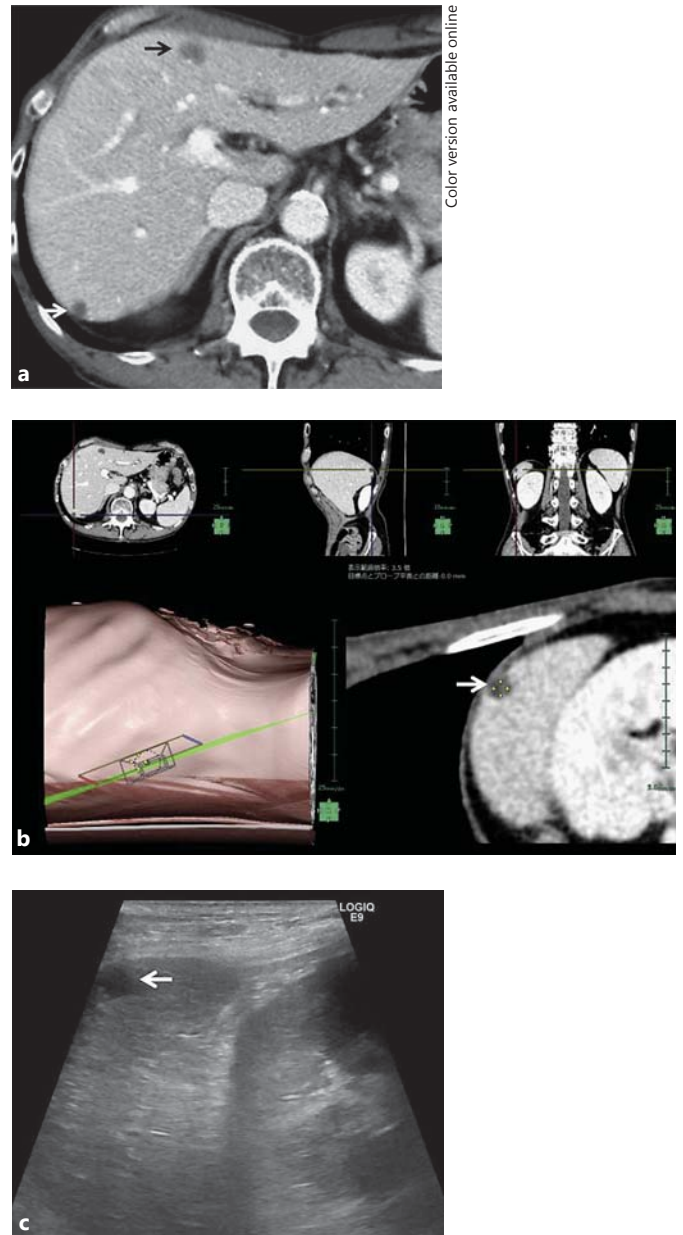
Imaging of a 66-year-old man with liver cysts. a Transverse portal phase CT shows two cysts (arrows) in segment III and VI of the liver. b Screen shot shows setting windows for VINCENT. Upper images show the transverse, sagittal, and coronal views for the cyst in segment VI. The lower left image shows that the transducer angle in the plane of the body trunk indicates images obtained from the subcostal view. The lower right image displays the virtual US image and the cyst as low-density area. c B-mode US image corresponds to the virtual US image. The cyst is shown as low echoic area (arrow). Our US beginners missed this cyst without using VINCENT because the rib bone hid it.
